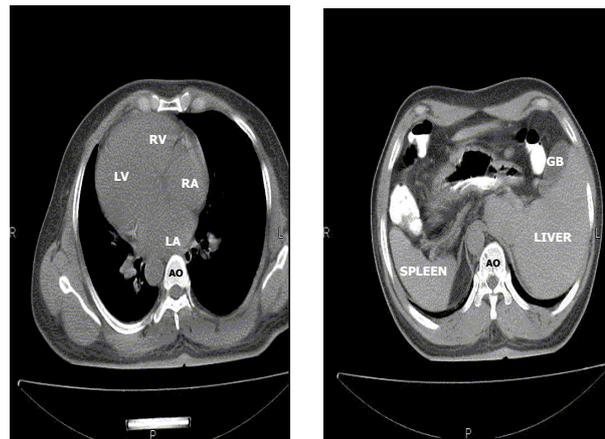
Computed Tomogram Scan Showing (a) Dextrocardia and (b) Abdominal Visceral Situs Inversus.
